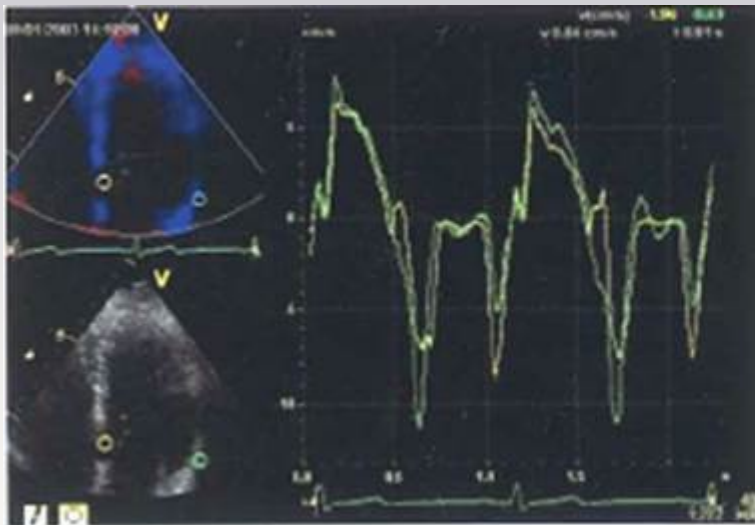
Example of the assessment of left ventricular (LV) dyssynchrony in a normal individual. In the color-coded tissue Doppler images (A, four-chamber view), sample volumes are placed in the basal part of the septum and lateral wall. Velocity graphs derived from the velocities measured in sample volumes are presented in the right panel of A. In this normal individual, LV dyssynchrony is not present, as indicated by a septal-to-lateral delay in systolic velocity (arrow) of 0 ms. (B) The accompanying velocity encoded magnetic resonance imaging is presented. Similar to TDI, sample volumes are placed in the basal part of the septum and lateral wall. The velocity graphs are presented in panel C, confirming the absence of LV dyssynchrony (septal-to-lateral delay 0 ms).
